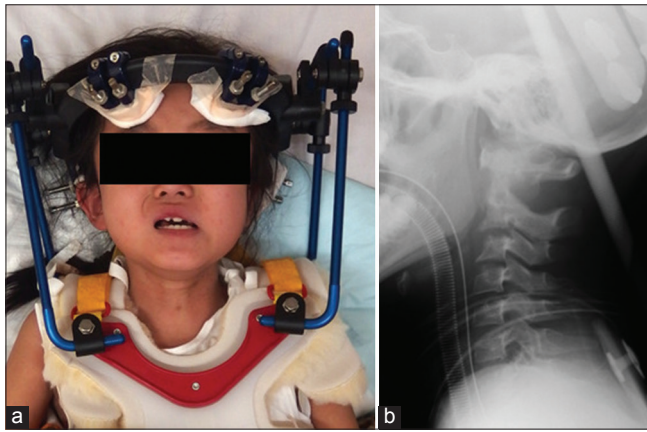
Photograph (a) and radiography (b) of the patient undergoing reduction treatment under general anesthesia.
